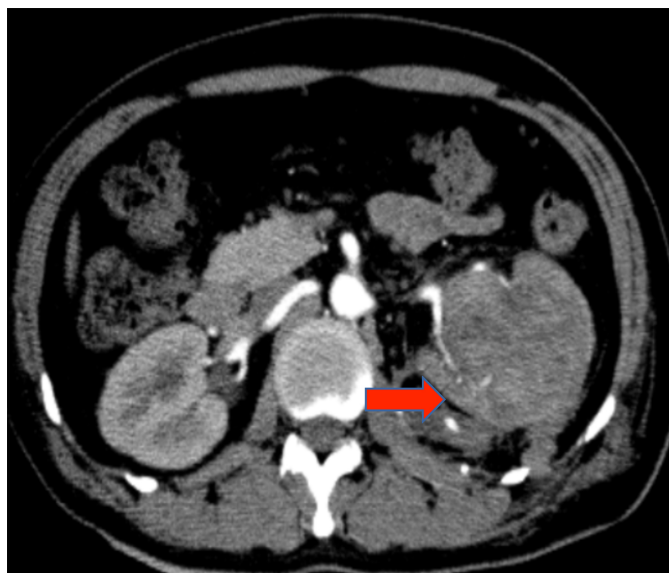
CT renal angiogram (axial section) showing reduced parenchymal enhancement of the left kidney compared to the normal right side and complex heterogeneous material filling the pelvicalyceal system.
